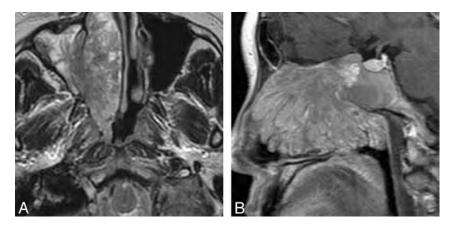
Woman, 56 years old. *A*, Axial T2-weighted MR imaging shows a heterogeneously isointense signal mass in the right nasal cavity with associated obstructive maxillary sinusitis. *B*, Lesion shows a characteristic "cerebriform" appearance on sagittal enhanced TI-weighted MR imaging with associated obstructive sphenoid sinusitis.
